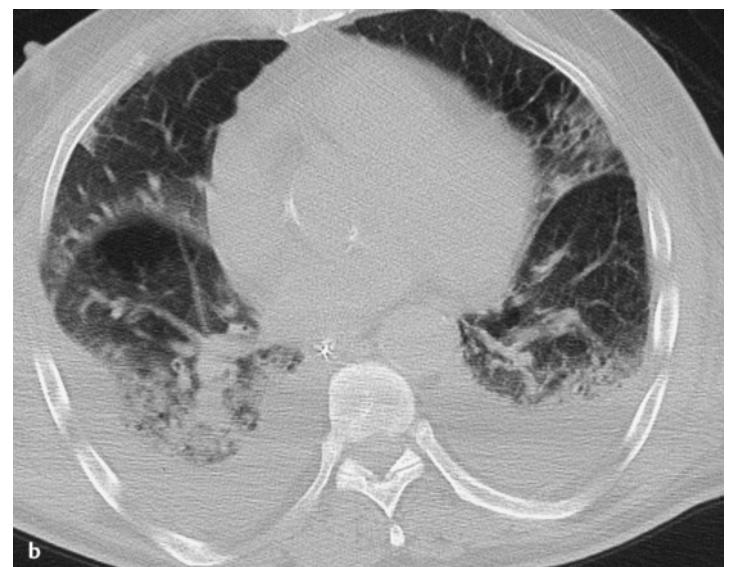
CT in overhydration. Diffuse, finely nodular, and septal shadowing. Prominent azygos vein (white arrow) and effusion in the costophrenic angle. Note that individual mediastinal lymph nodes are enlarged.
